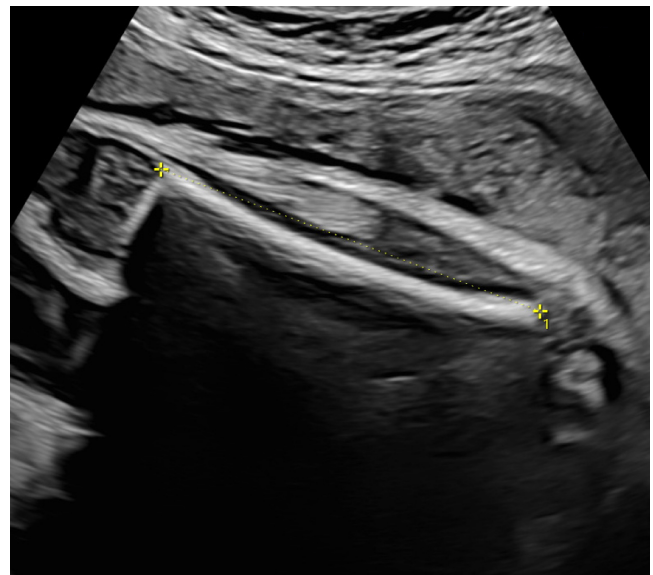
Sonographic measurement of fetal femur length in third trimester.
